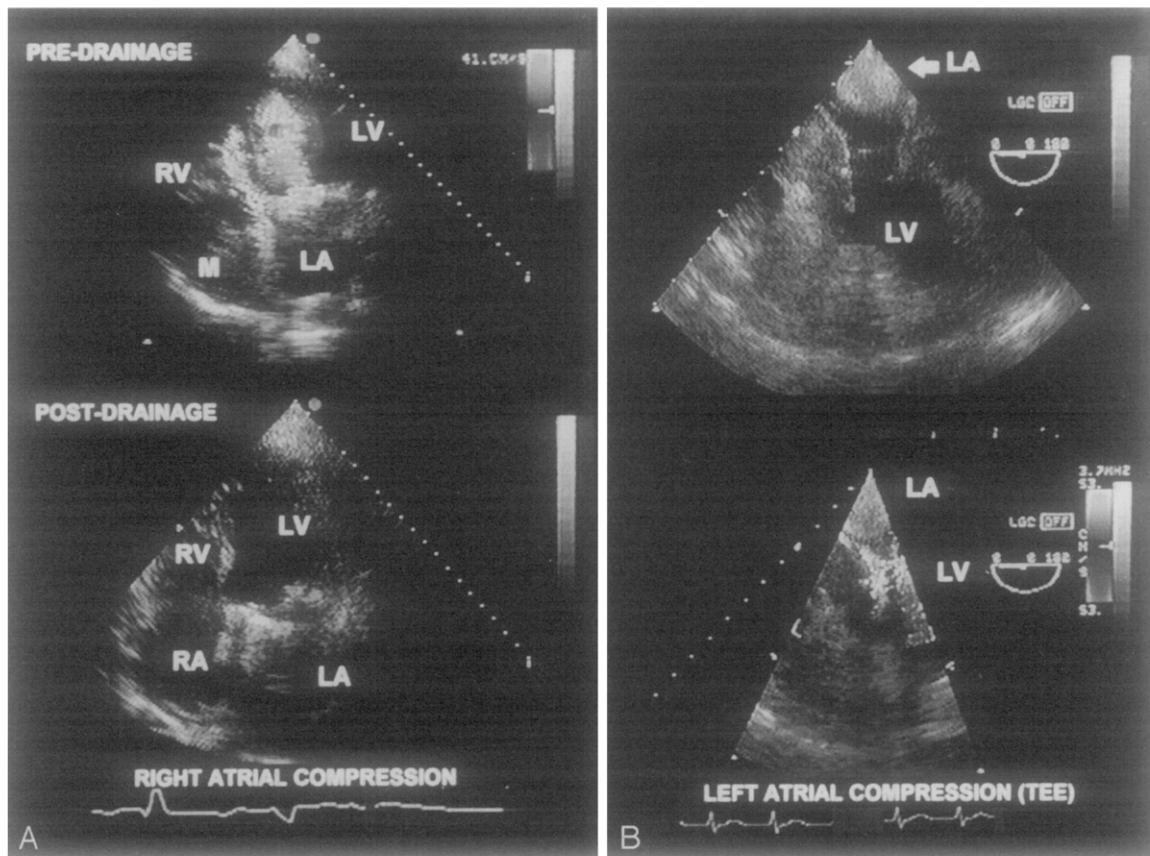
Atrial tamponade in two different hypotensive patients after surgery. A, Isolated right atrial tamponade (*top*). B, Isolated left atrial tamponade. Note deviation of blood flow around obstructing extrinsically compressing masses (*M* and *arrow*) in color Doppler pictures. A, Effect of removing hematoma on reexpansion of right atrial cavity (*bottom*). In both patients, evacuation of hematoma relieved hypotension and facilitated recovery. (*RV*, Right ventricle; *LV*, left ventricle; *RA*, right atrium; *LA*, left atrium.)
